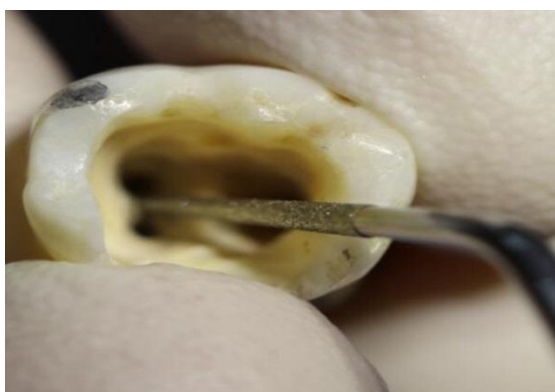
Troughing of the MM using an ultrasonic tip
